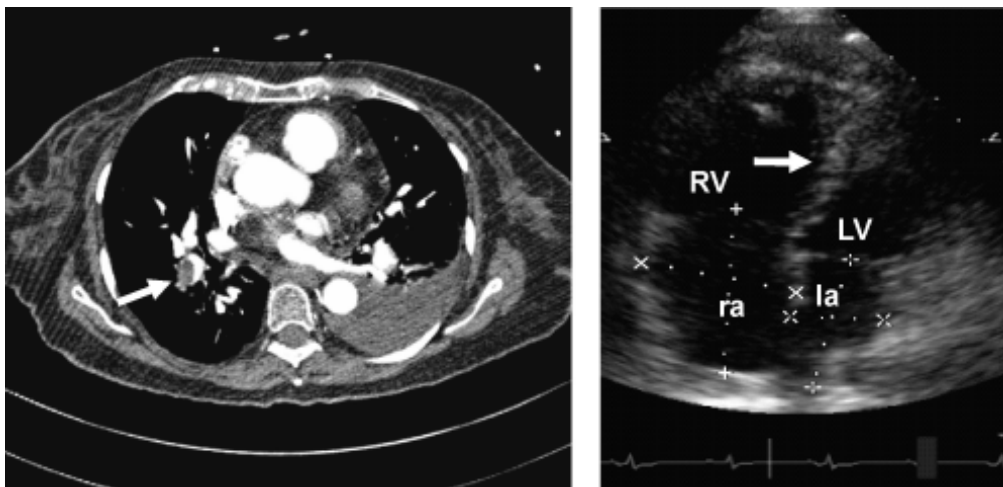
A. Thoracic computerized angio-tomography where the abnormal filling of a branch of the right pulmonary artery can be observed (arrow). B. Echocardiogram where dilation of the right ventricle with displacement of the interventricular septum to the left can be observed (arrow). RV: right ventricle. LV: left ventricle. ra: right atrial. la: left atrial.
